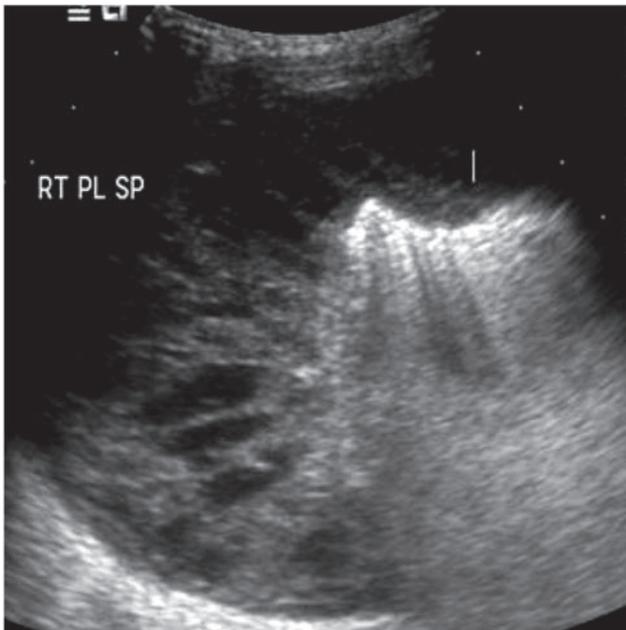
An ultrasound of the chest showing a semi-solid right pleural collection that is hypoechoic and multiple thin septations within it.
